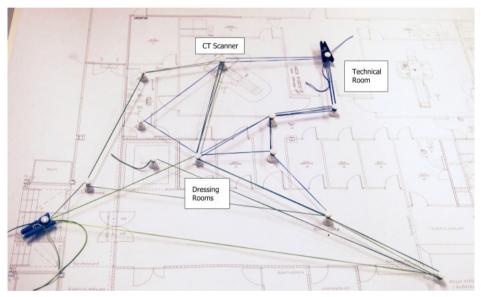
Knitting game made by the CT scan activity. The blue lines are nurse movements and the green are patients
